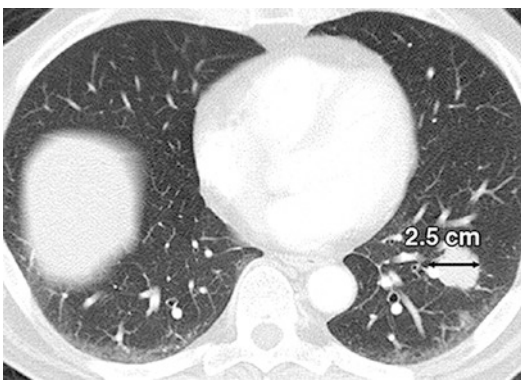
Measurable lesions according to RECIST. CT scan of chest in 64-year-old man with colon cancer. Lobulated nodule in left lower lobe representing metastasis measures 2.5 cm in longest diameter (arrow), meeting criteria for measurable lesion on CT (longest diameter ≥ 10 mm). (Reprinted with permission from AJR Am J Roentgenol. 2010;195: 281–289)
